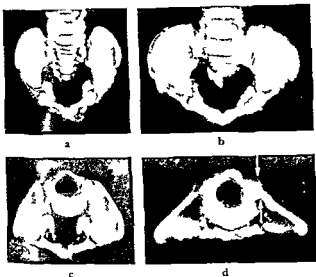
Pelvic preparations from a normal (a, c) and a mongoloid (b, d) newborn. a) b) in the same projection as at roentgen examination c) d) axial projections. In the mongoloid pelvis the iliac bones lie almost in the frontal plane — outwardly rotated in the sacro-iliac joints but the dorsal part of the alae is in the sagittal plane (→)
